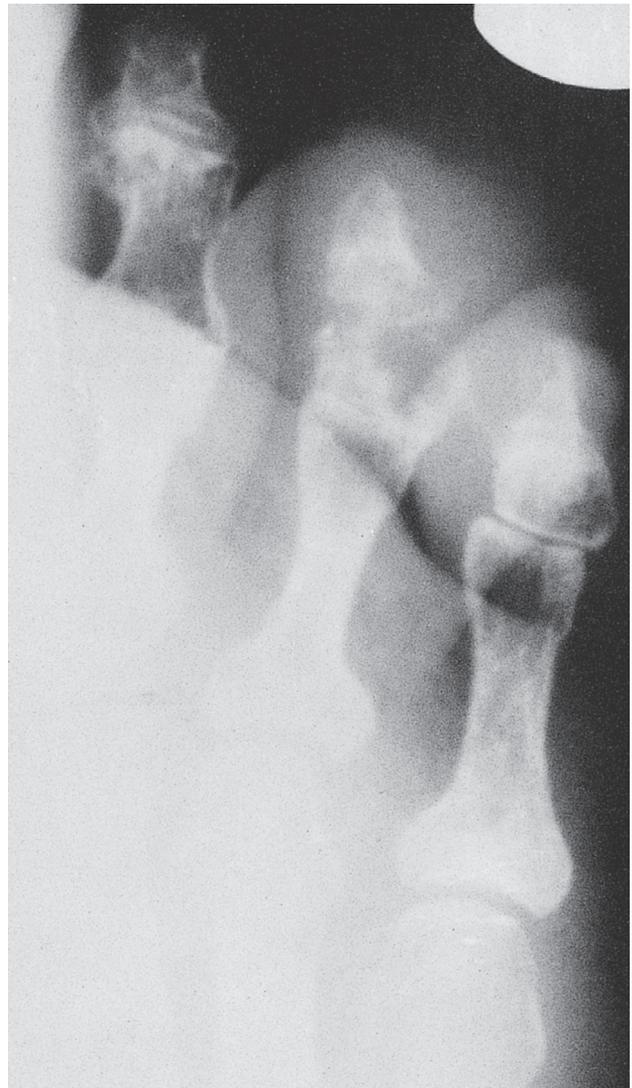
X-ray image of bony erosions involving toes affected by chronic gout. From *Orthopaedic Pathology*, (2nd ed., p. 593) by V. J. Vigorita, 2008, Philadelphia: Lippincott Williams & Wilkins. Reproduced with permission.
